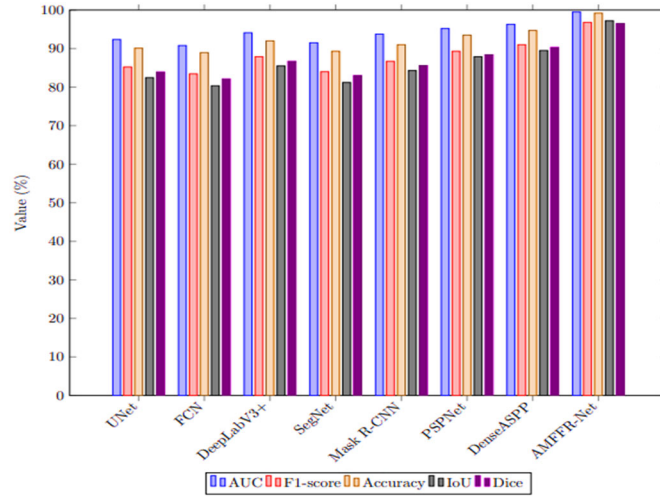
Performance analysis plot for MRI image dataset.
